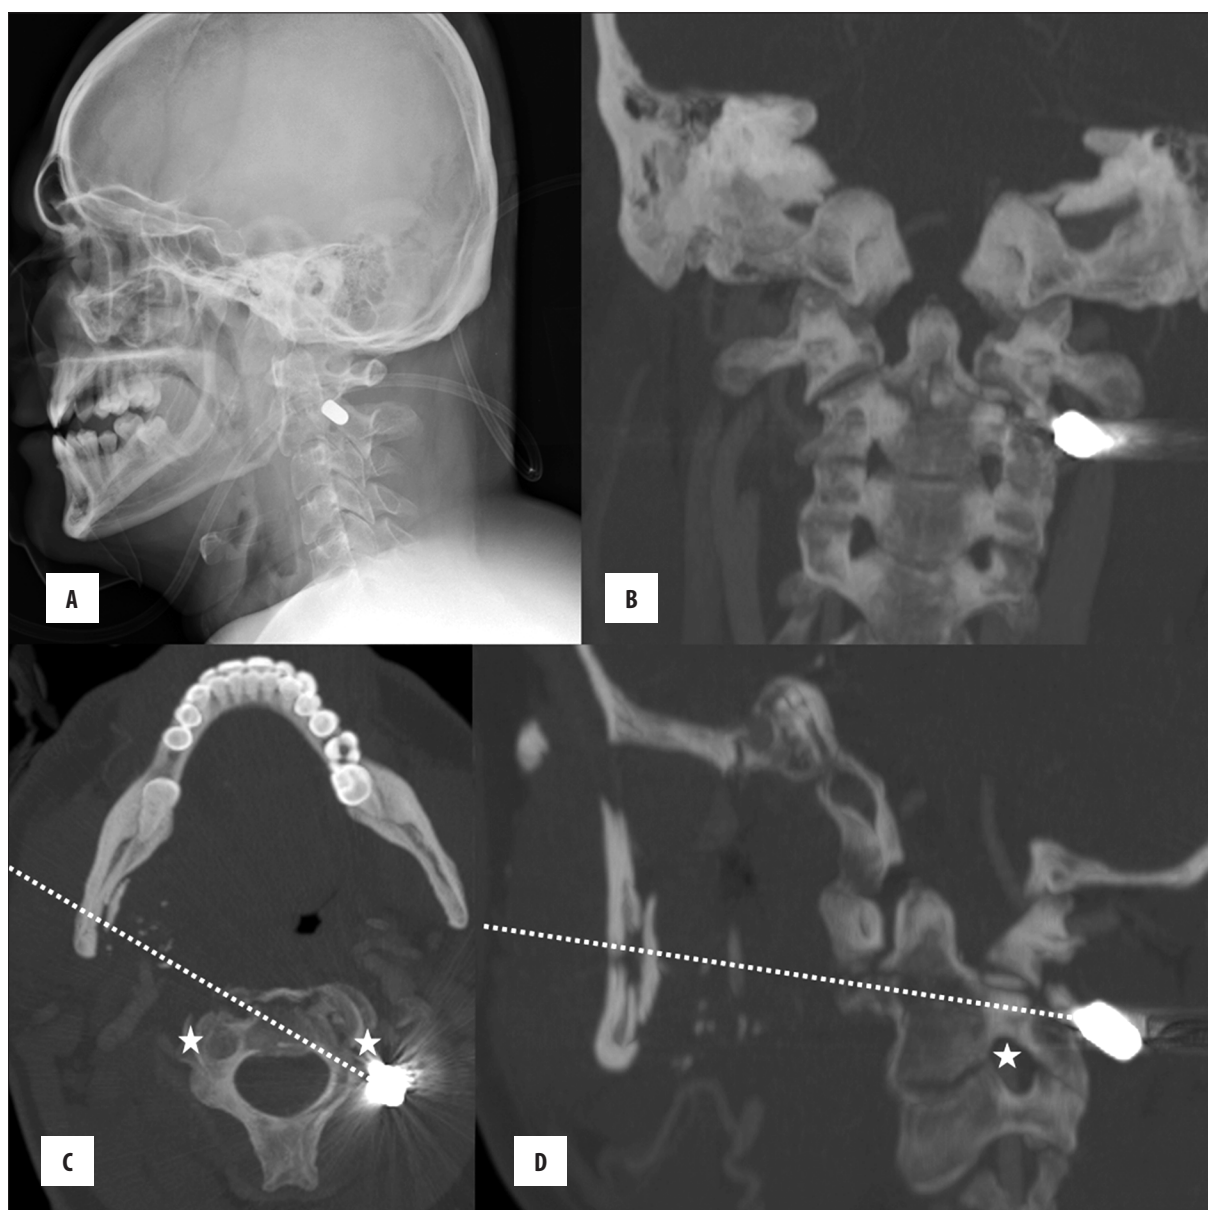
Conventional radiography shows the bullet in projection close proximity to the C1/C2 facet joint (A). Coronal (B), axial (C) and sagittal (D) CT reformations of the cervical spine show the trajectory of the bullet and the resulting complex fracture of the basis of the C2 vertebra (Benzel fracture Type 2 [4]) leaving the cervical spinal cord and left vertebral artery intact. The dotted lines indicate the bullet path (C, D), the asterisks indicate sensible vessel structures like the vertebral artery (C, D).
